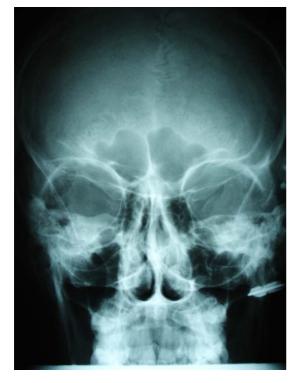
PA radiograph (PA) showing metal key in the left condyle region.
